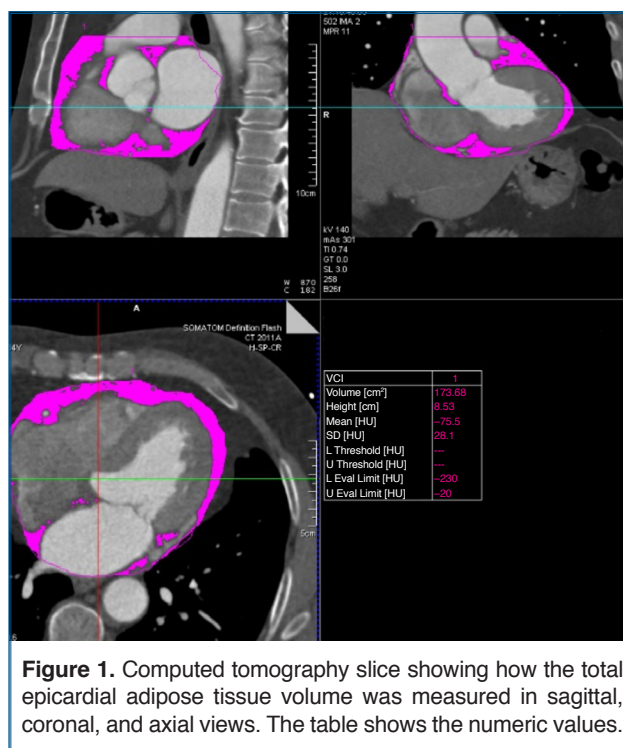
Computed tomography slice showing how the total epicardial adipose tissue volume was measured in sagittal, coronal, and axial views. The table shows the numeric values.
